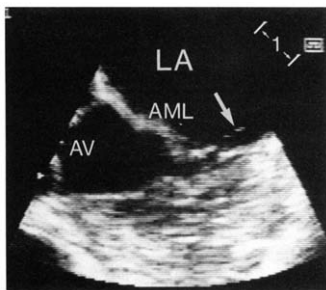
Mitral valve in a normal volunteer. The transesophageal image plane is tangential to the mitral annulus, so that the posterior leaflet appears very short. A thin strand (arrow) prolapses into the left atrium (LA) from the tip of the anterior mitral leaflet (AML). A 1-cm distance is indicated diagonally to the right of the left atrium. AV = aortic valve.
